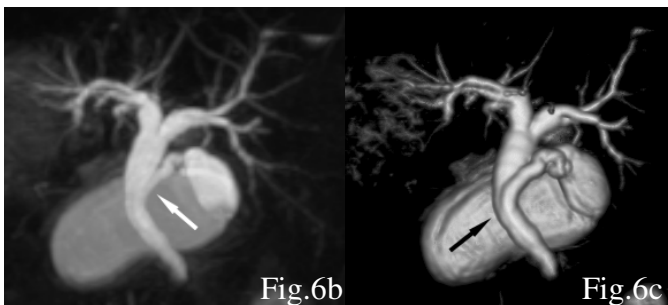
A 27-year-old woman with gallstones; images are from free-breathing navigator-triggered 3D T2-weighted TSE MRCP. (b) This MIP image viewed from the left dorsal side rather poorly shows the cystic duct (*arrow*) located dorsal to the extrahepatic bile duct probably draining from the dorsal side into the middle extrahepatic bile duct. (c) This VR image viewed from the left dorsal side (same angle as (b)) clearly displays that the cystic duct (*arrow*) drains into the left posterior side of the lower extrahepatic bile duct from the dorsal side.
